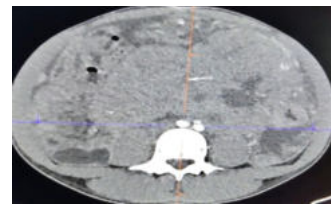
2; Axial Contrast Enhanced CT images showing smooth homogenous peritoneal thickening with Ascitis.
